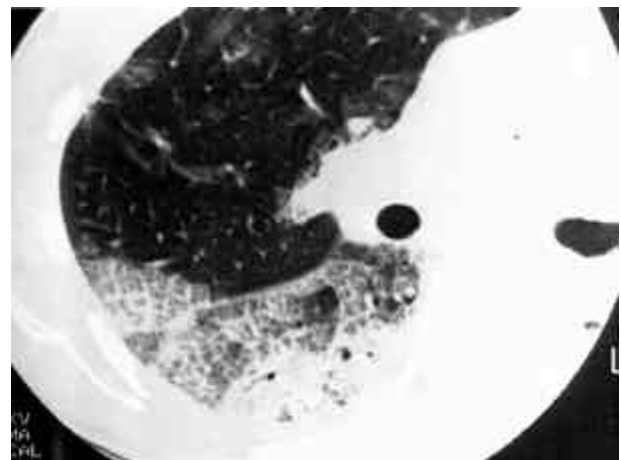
High-resolution CT of a 34-year-old woman with dermatomyositis shows predominantly ground-glass opacity and also consolidation at dependent portion.
